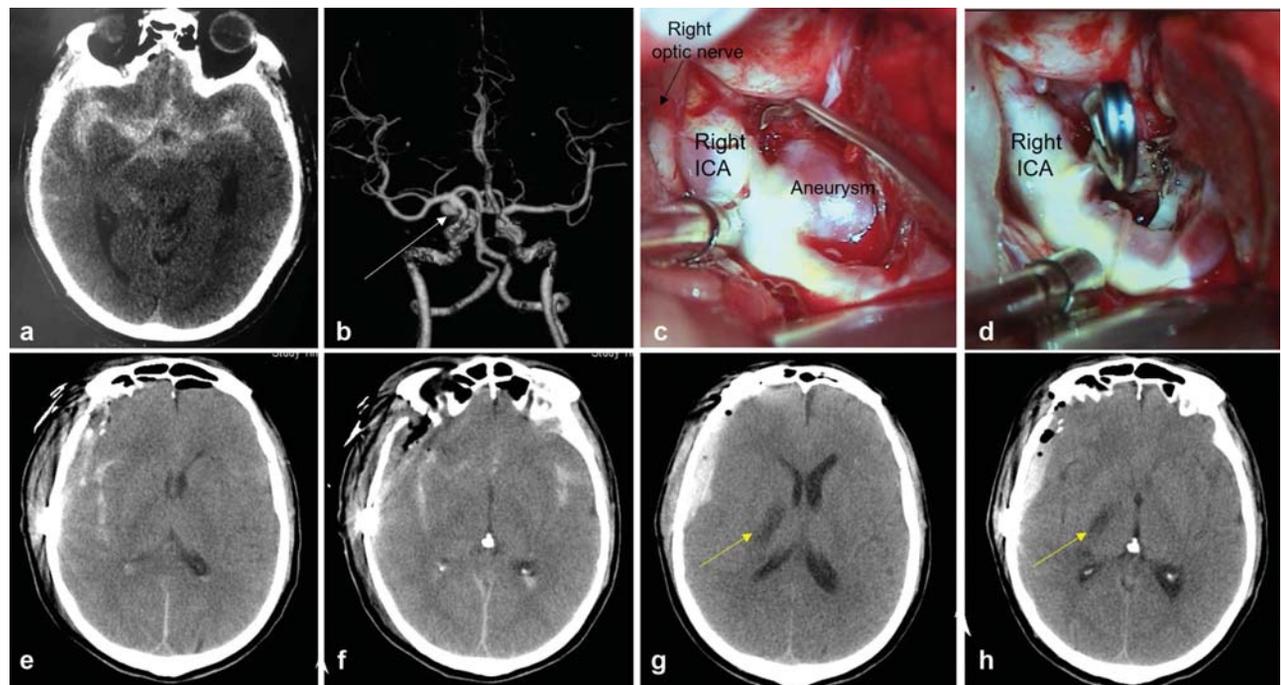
A 69-year-old male patient. Preoperative diagnosis is right choroidal artery aneurysm. (a) Preoperative computed tomography (CT) showed subarachnoid hemorrhage. (b) Preoperative computed tomography angiography showed choroidal artery aneurysm. (c) Aneurysm. (d) The aneurysm was clipped. (e, f) CT on the first day after surgery. (g, h) On day 10 after surgery, the CT shows a right basal ganglia infarction indicative of an anterior choroidal artery syndrome (arrows). ICA, internal carotid artery.
